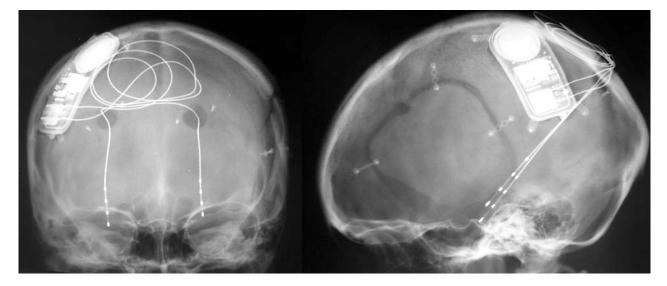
Postoperative X-rays (antero-posterior and lateral views) of one of our patients demonstrating the implanted RNS system with two depth leads. The depth leads have been implanted through bilaterally placed burr holes. A cranitotomy defect for previous resection is also noted
